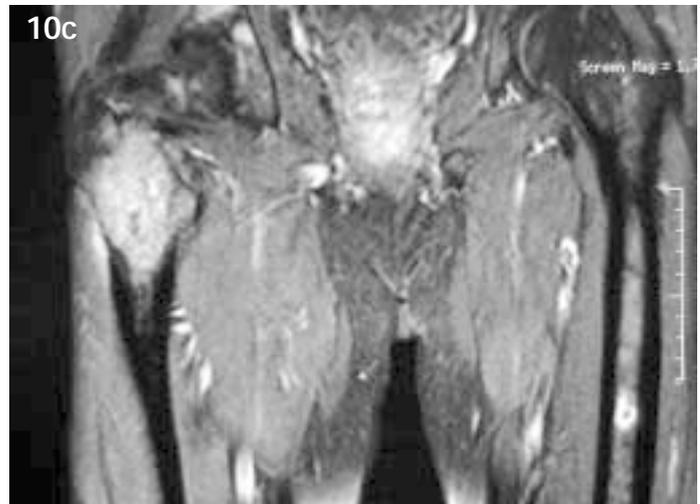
63-year-old man with biopsy-proven adenocarcinoma of unknown origin. (a) Anterior radiograph shows an ill-marginated osteolytic lesion in the right trochanteric region. Coronal (b) T1-weighted and (c) enhanced fat-suppressed T1-weighted MR images show the true extent of the right femoral lesion which involves the lesser trochanter, as well as a small radiographically-occult lesion in the left upper femoral shaft. Both metastatic lesions are T1 hypointense, T2 hyperintense (not shown) and display marked enhancement.
